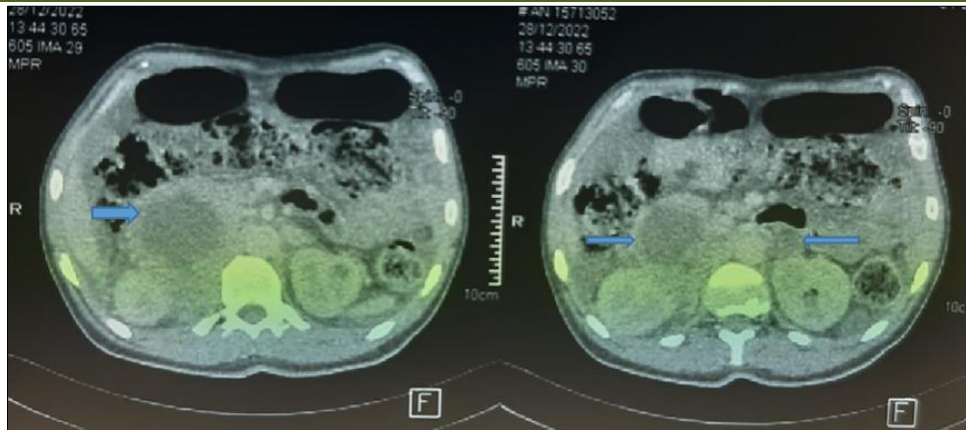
Adrenal CT-Scan: bilateral adrenal masses (blue arrow).
